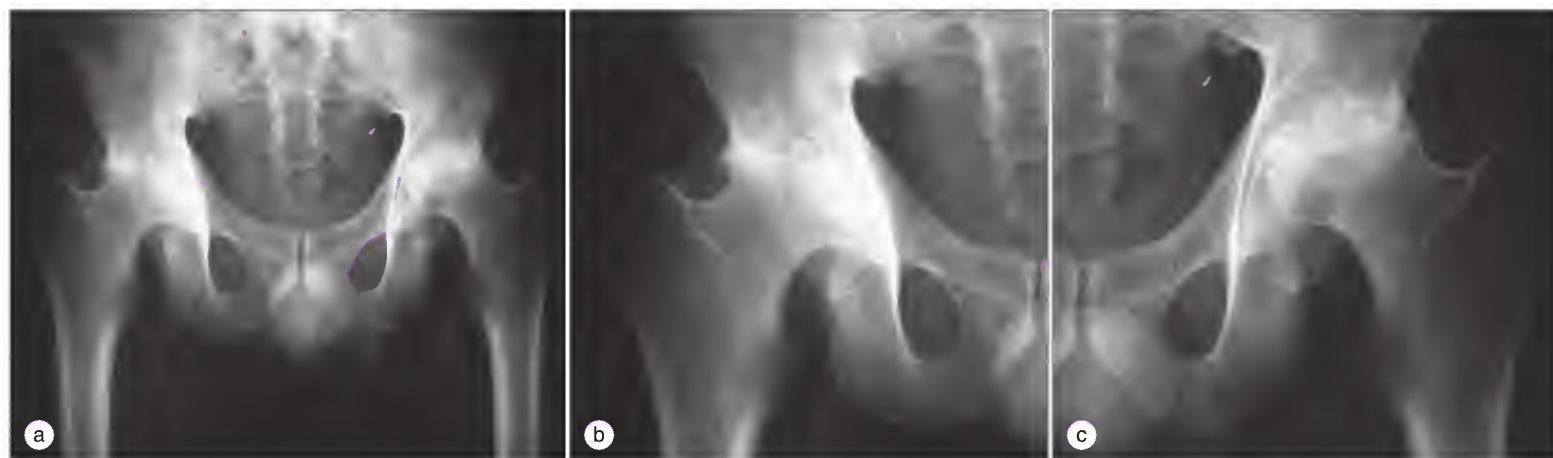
(a to c) Radiographs of the pelvis showing the typical hip involvement leading to joint destruction.
